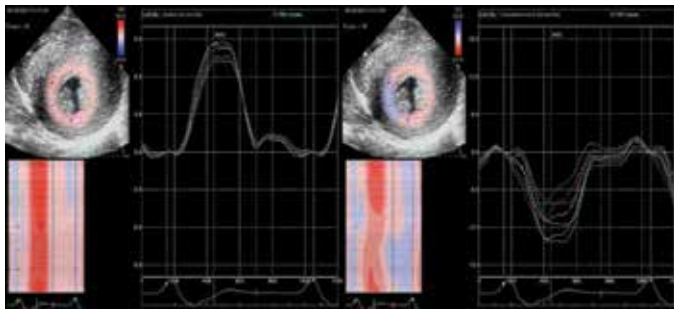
Reduced radial and circumferential strain values of the mid ventricular region by 2D speckle tracking echocardiography.
